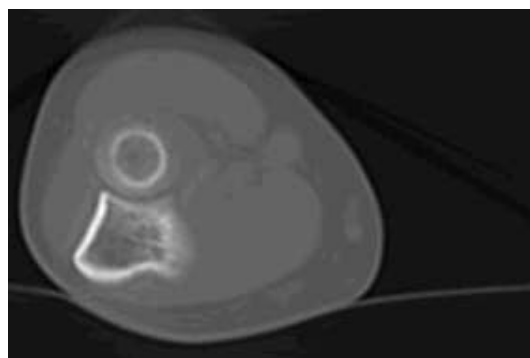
CT Data: An axial slice from the CT scan.
